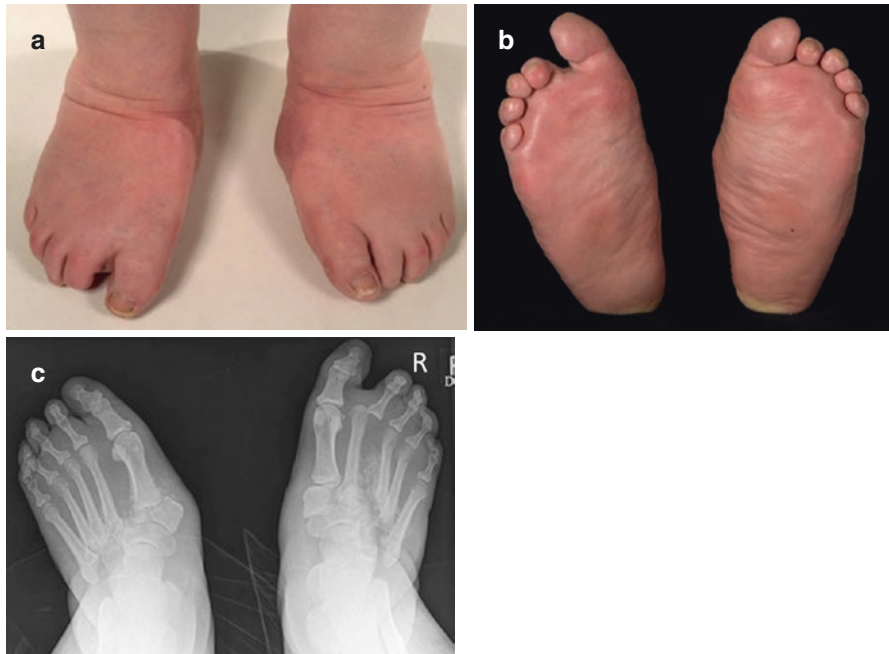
(a) A patient presenting with bilateral acute red hot swollen Charcot feet (b) showing rocker-bottom deformity of each foot (c) corresponding dorsoplantar radiograph showing bilateral metatarsal-tarsal fracture dislocation and right second metatarsal-phalangeal dislocation
